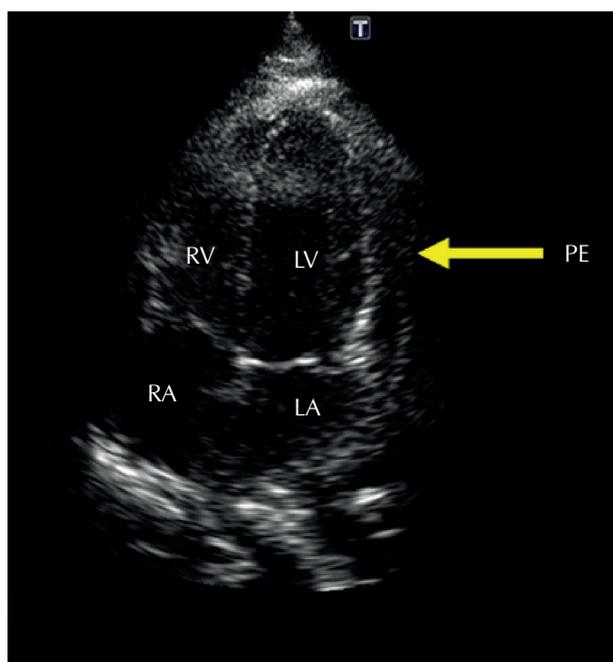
Transthoracic echocardiogram (4-chamber apical view) showing reduction in the amount and echogenicity of the pericardial effusion 5 days after drainage. RV: right ventricle; LV: left ventricle; PE: pericardial effusion; RA: right atrium; LA: left atrium.
